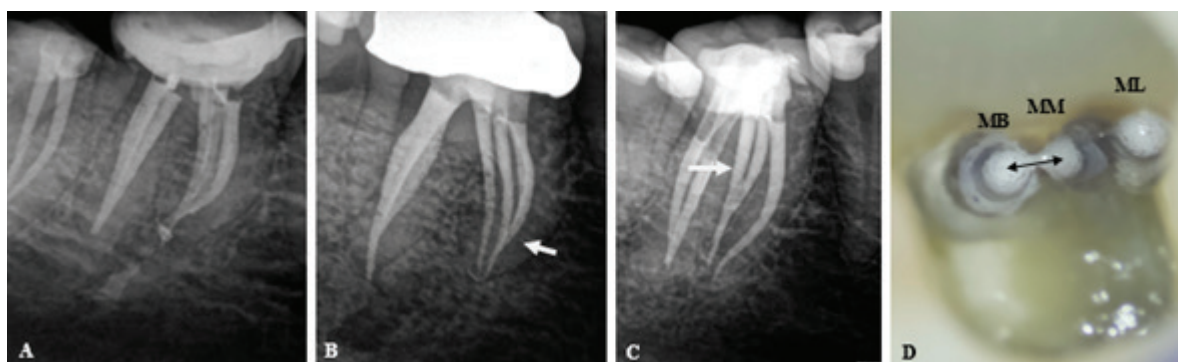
MM root canal configurations encountered during clinical management of mandibular first molars in South African individuals; (A) Postoperative periapical radiograph after obturation of five root canal systems in a right mandibular first molar. Note that the three separate mesial root canal systems join in the apical third of the root to exit in a combined apical foramen (3-3-1 configuration in mesial root); (B) Postoperative periapical radiograph after obturation of five root canal systems in a right mandibular first molar. Note that the MB and MM root canal systems join in the apical third of the root (white arrow) to exit in a combined apical foramen, while the ML canal system remains separate (3-3-2 configuration in mesial root); (C) Postoperative periapical radiograph after obturation of five root canal systems in a right mandibular first molar. Note that the ML and MM root canal systems join in the middle third of the root (white arrow) to exit in a combined apical foramen, while the MB canal system remains separate (3-2-2 configuration in mesial root); (D) High-magnification view of the mesial aspect of the pulp chamber of a left mandibular first molar. Three mesial root canal systems were located; the MB and MM orifices are very close together (arrow) and joined as one canal in the coronal third of the root.
